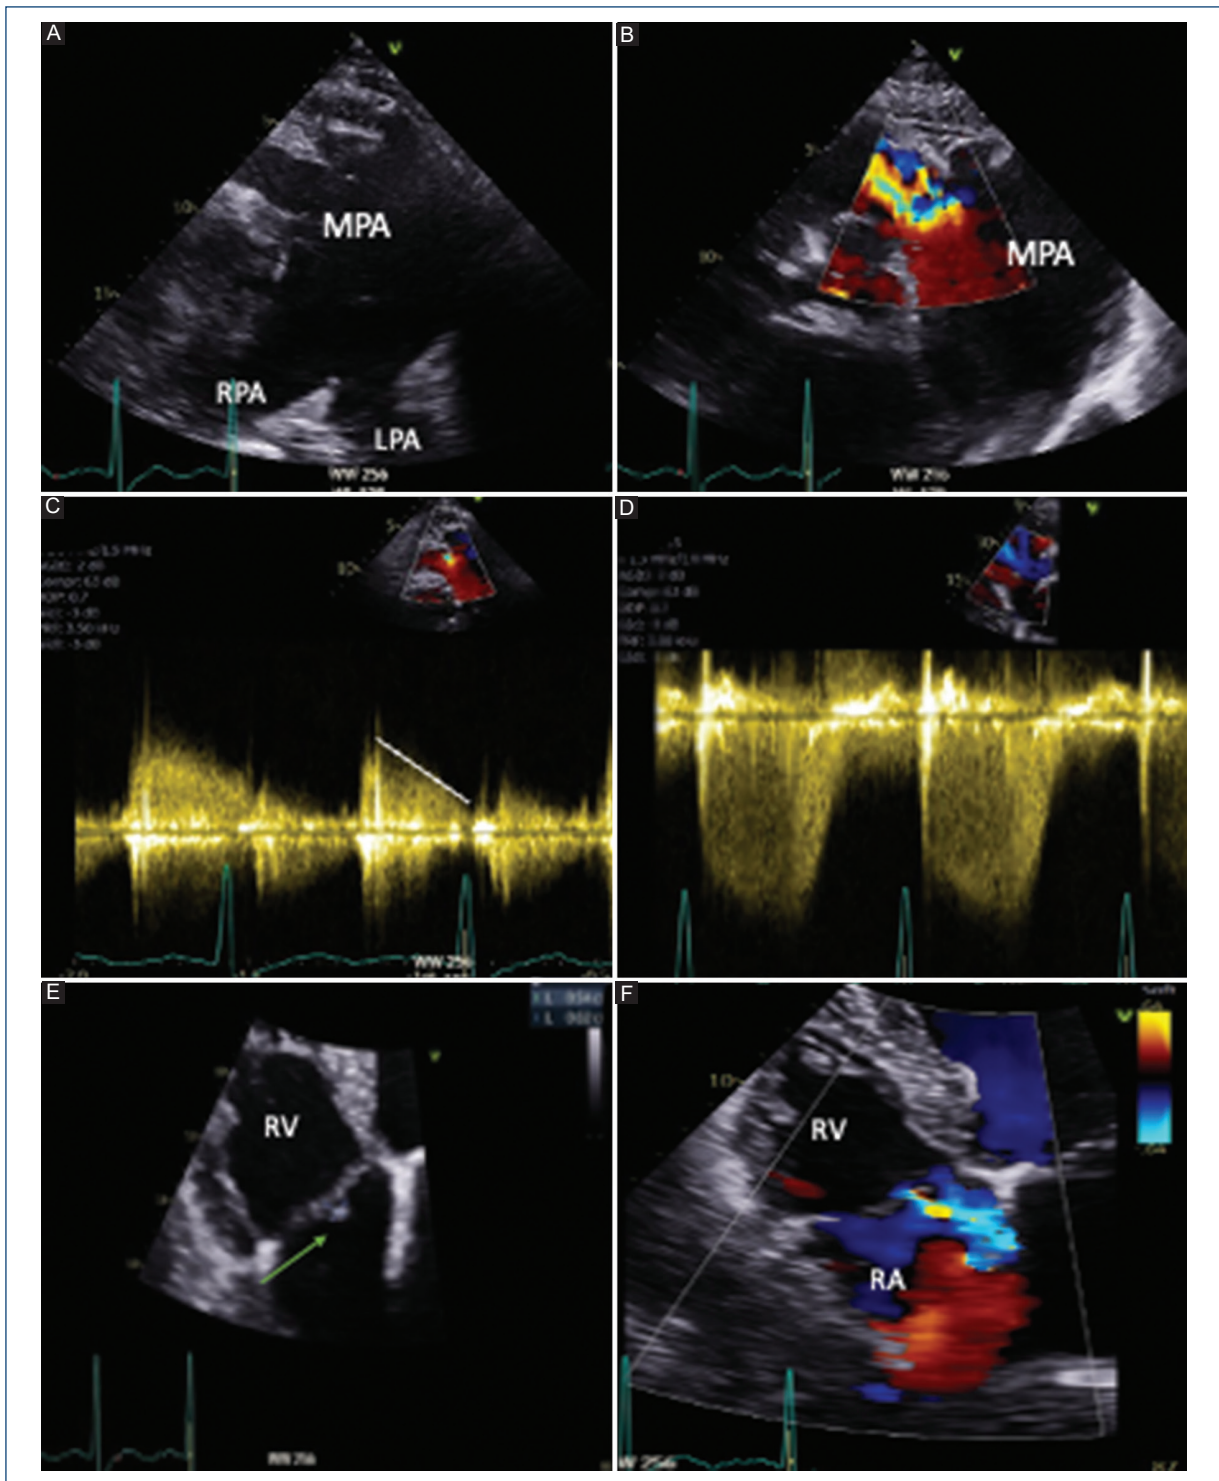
A: TTE 2D imaging of the main pulmonary artery and branch pulmonary arteries in the parasternal short-axis view. B: color Doppler of the pulmonary valve in the parasternal short-axis view, demonstrating severe pulmonary regurgitation. C: continuous wave (CW) Doppler of pulmonary valve regurgitation with pressure half-time (PHT, white line) demonstrating rapid flow deceleration during diastole, indicating severe regurgitation. D: CW Doppler of the tricuspid valve in the parasternal short-axis view, showing a maximum velocity of 3.3 m/s and an estimated right ventricular systolic pressure of 60 mmHg. E: apical 4-chamber view (right ventricular-focused view) showing an independently mobile echodensity on the atrial side of the tricuspid valve, measuring 0.5 mm × 0.6 mm (yellow arrow). F: color Doppler interrogation of the tricuspid valve in the apical 4-chamber view, highlighting moderate regurgitation. AA: ascending aorta; DA: descending aorta; MPA: main pulmonary artery; RPA: right pulmonary artery; LPA: left pulmonary artery; RA: right atrium; RV: right ventricle.
